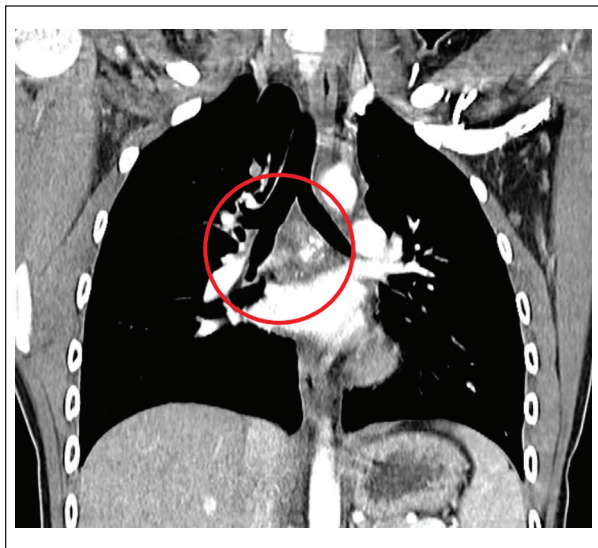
Coronal image of computed tomography scan of thorax after treatment with steroids and itraconazole showing an interval decrease in size of subcarinal soft tissue mass to 1.6-cm and hilar lymph nodes and improved patency of the right middle lobe bronchus.
